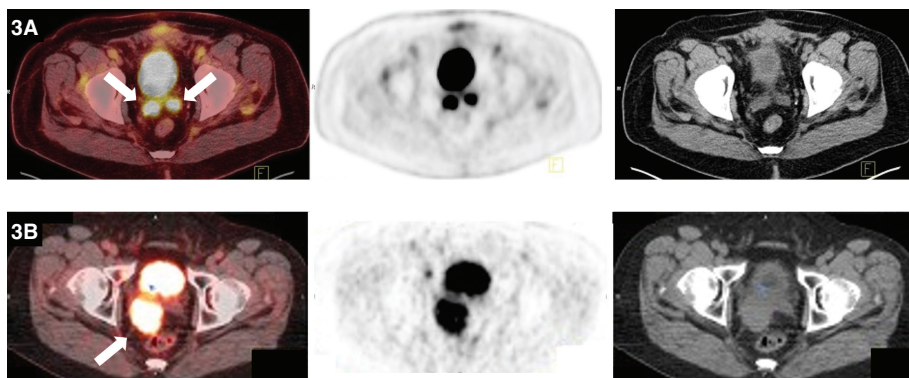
Seminal vesicles. FDG PET/CT demonstrates uptake within the bilateral seminal vesicles (thick solid arrows) in one patient (row 3A) and within an enlarged right seminal vesicle (thick solid arrow) in another patient (row 3B). Biopsy was negative in the first patient suggesting that activity likely represented urinary reflux of radiotracer (3A). Biopsy was positive for a plasmacytoma in the second patient (3B).
